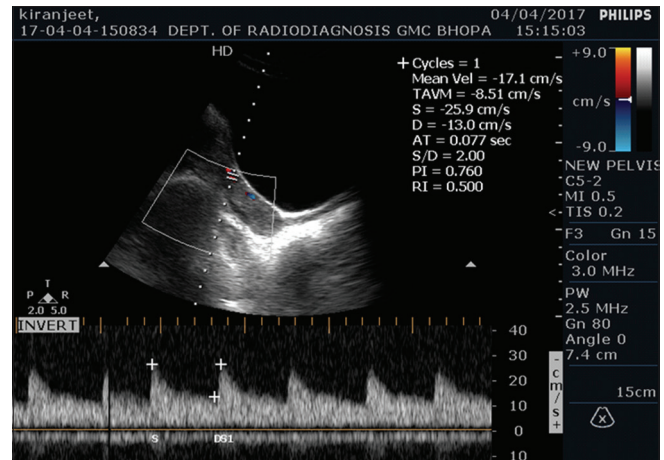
Color Doppler study showing elevated peak systolic velocity and end-diastolic velocity with reduced resistive index and pulsatility index in a case of polycystic ovary syndrome
